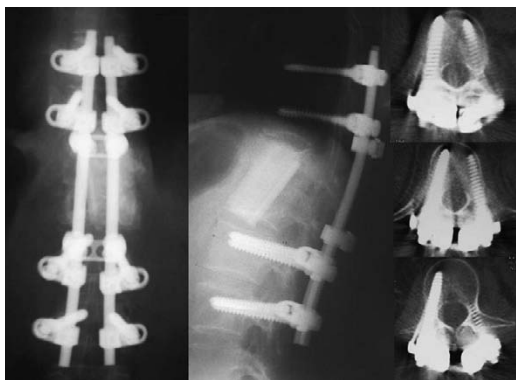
Postoperative plain radiographs and axial computed tomography images through the pedicle regions, demonstrating good location of the screws.
